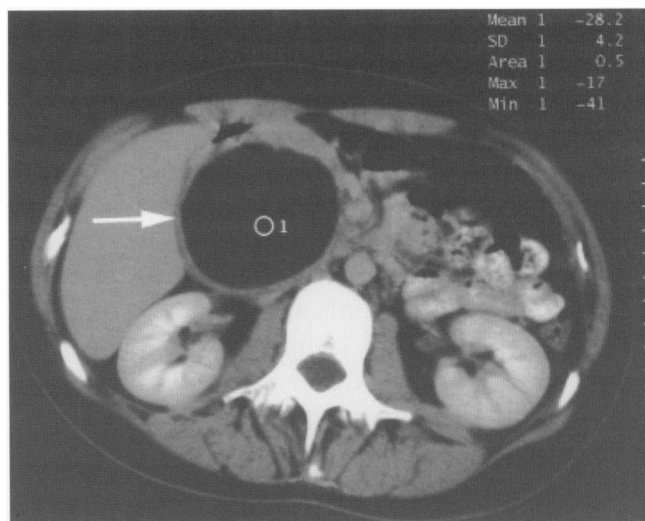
Axial intravenously enhanced CT scan of the upper abdomen with oral radiographic contrast, which shows the large retroperitoneal lymphangioma (short white arrow). An attenuation value has been measured, (less than 0) Hounsfield units (HU), signifying fatty content.
